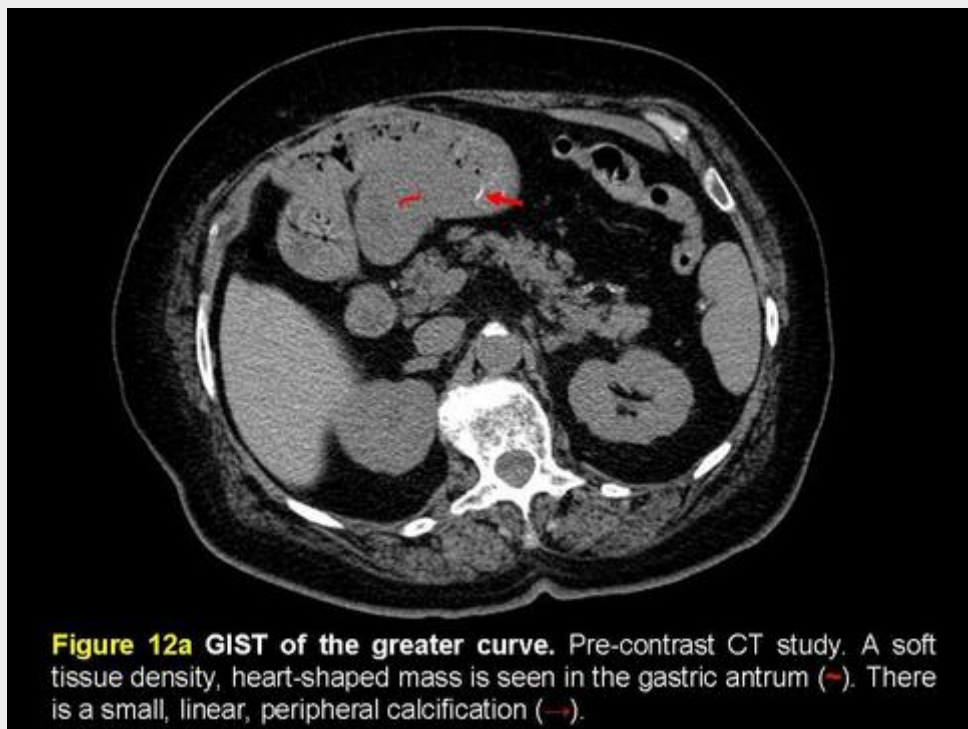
GIST of the greater curve. Pre-contrast CT study. A soft tissue density, heart-shaped mass is seen in the gastric antrum (→). There is a small, linear, peripheral calcification (→).
